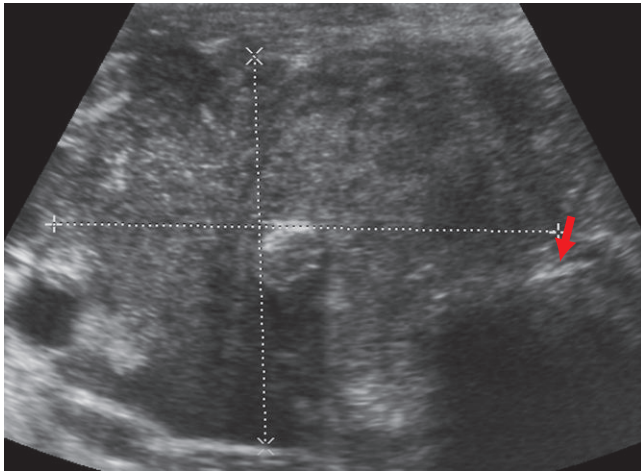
The transverse gray scale sonographic images show a large, solid, hypoechoic/heterogeneous thyroid mass in the right lobe with chunky calcification that abuts the trachea (arrow) and surrounds the carotid artery.
